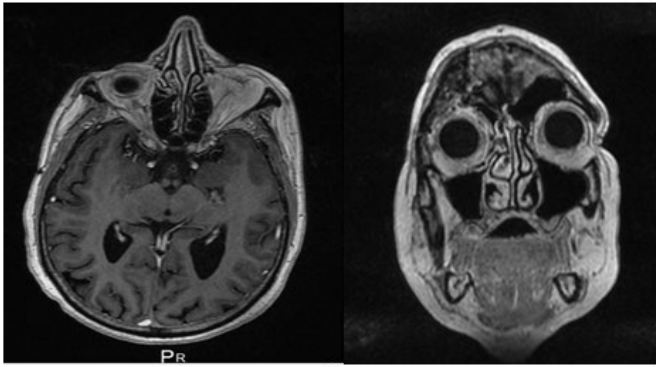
Images of post-treatment CT.
